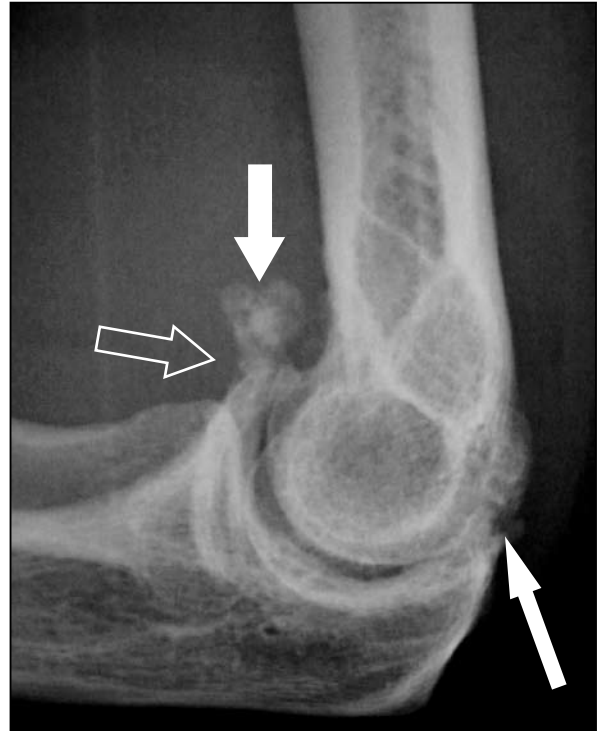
Lateral radiograph in a patient with elbow osteoarthritis. Osteophytes are present both on the coronoid (open arrow) and olecranon (narrow arrow) limiting both flexion and extension. There is a large loose body in the anterior joint space (filled arrow).
